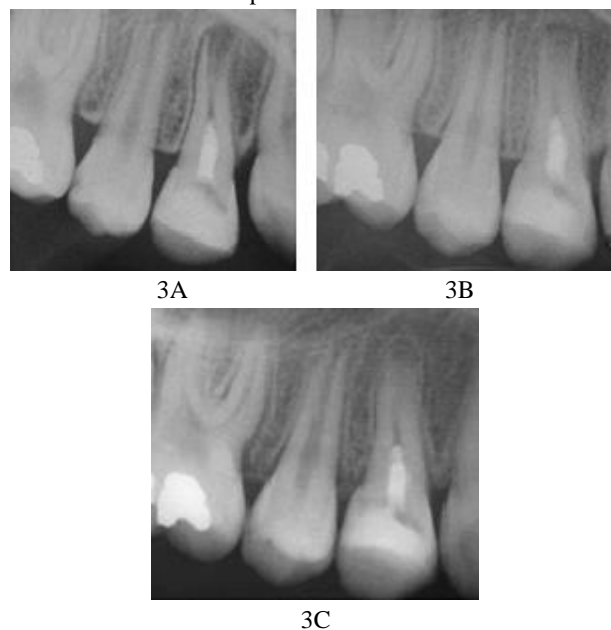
A: Post-regenerative endodontic procedure radiograph, B: 6 months follow-up, C: 12 months follow-up
